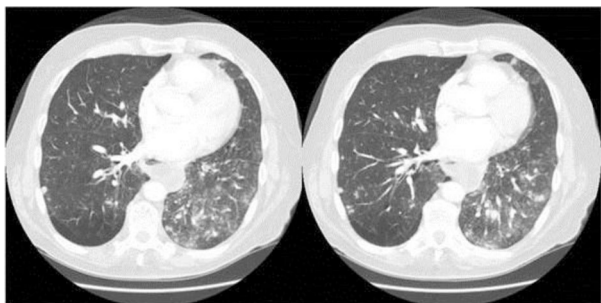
(a) and (b) CT chest showing left lower lobe pneumonia and bilateral but predominant left lower lobe pulmonary nodules.
